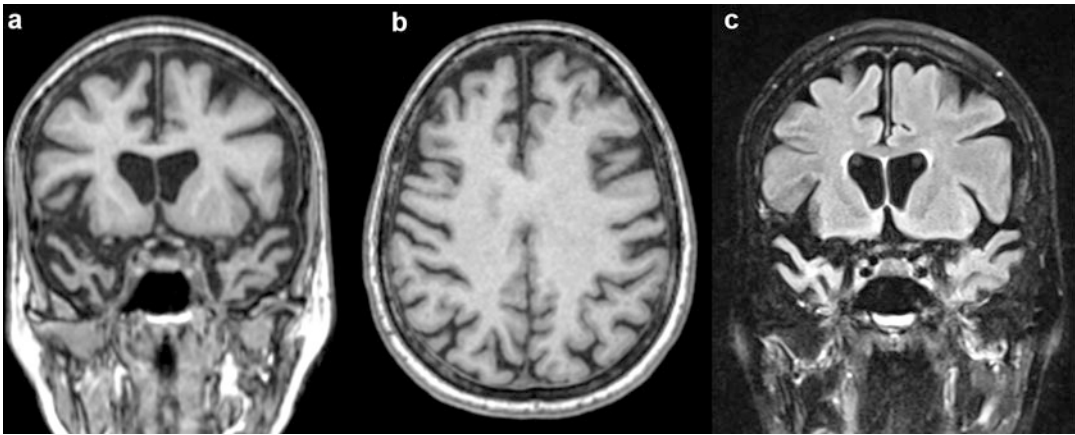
62-year-old woman undergoing imaging for progressive neurocognitive impairment. Coronal T1 (a) demonstrates atrophy most pronounced on the temporal poles with anterior temporal atrophy score of 3 on the right and 2 on the left hemisphere. Axial T1 (b) shows only mild atrophy of the frontal lobes. Coronal T2w FLAIR (c)
